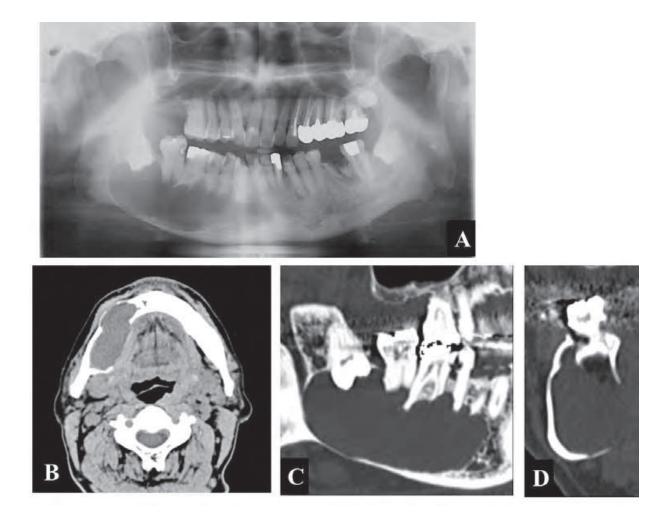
Panoramic radiograph image (A), and axial CT images (B) of a keratocystic odontogenic tumor in the mandible. Axial CT image (C) of the keratocystic odontogenic tumor with basal cell nevus syndrome.
